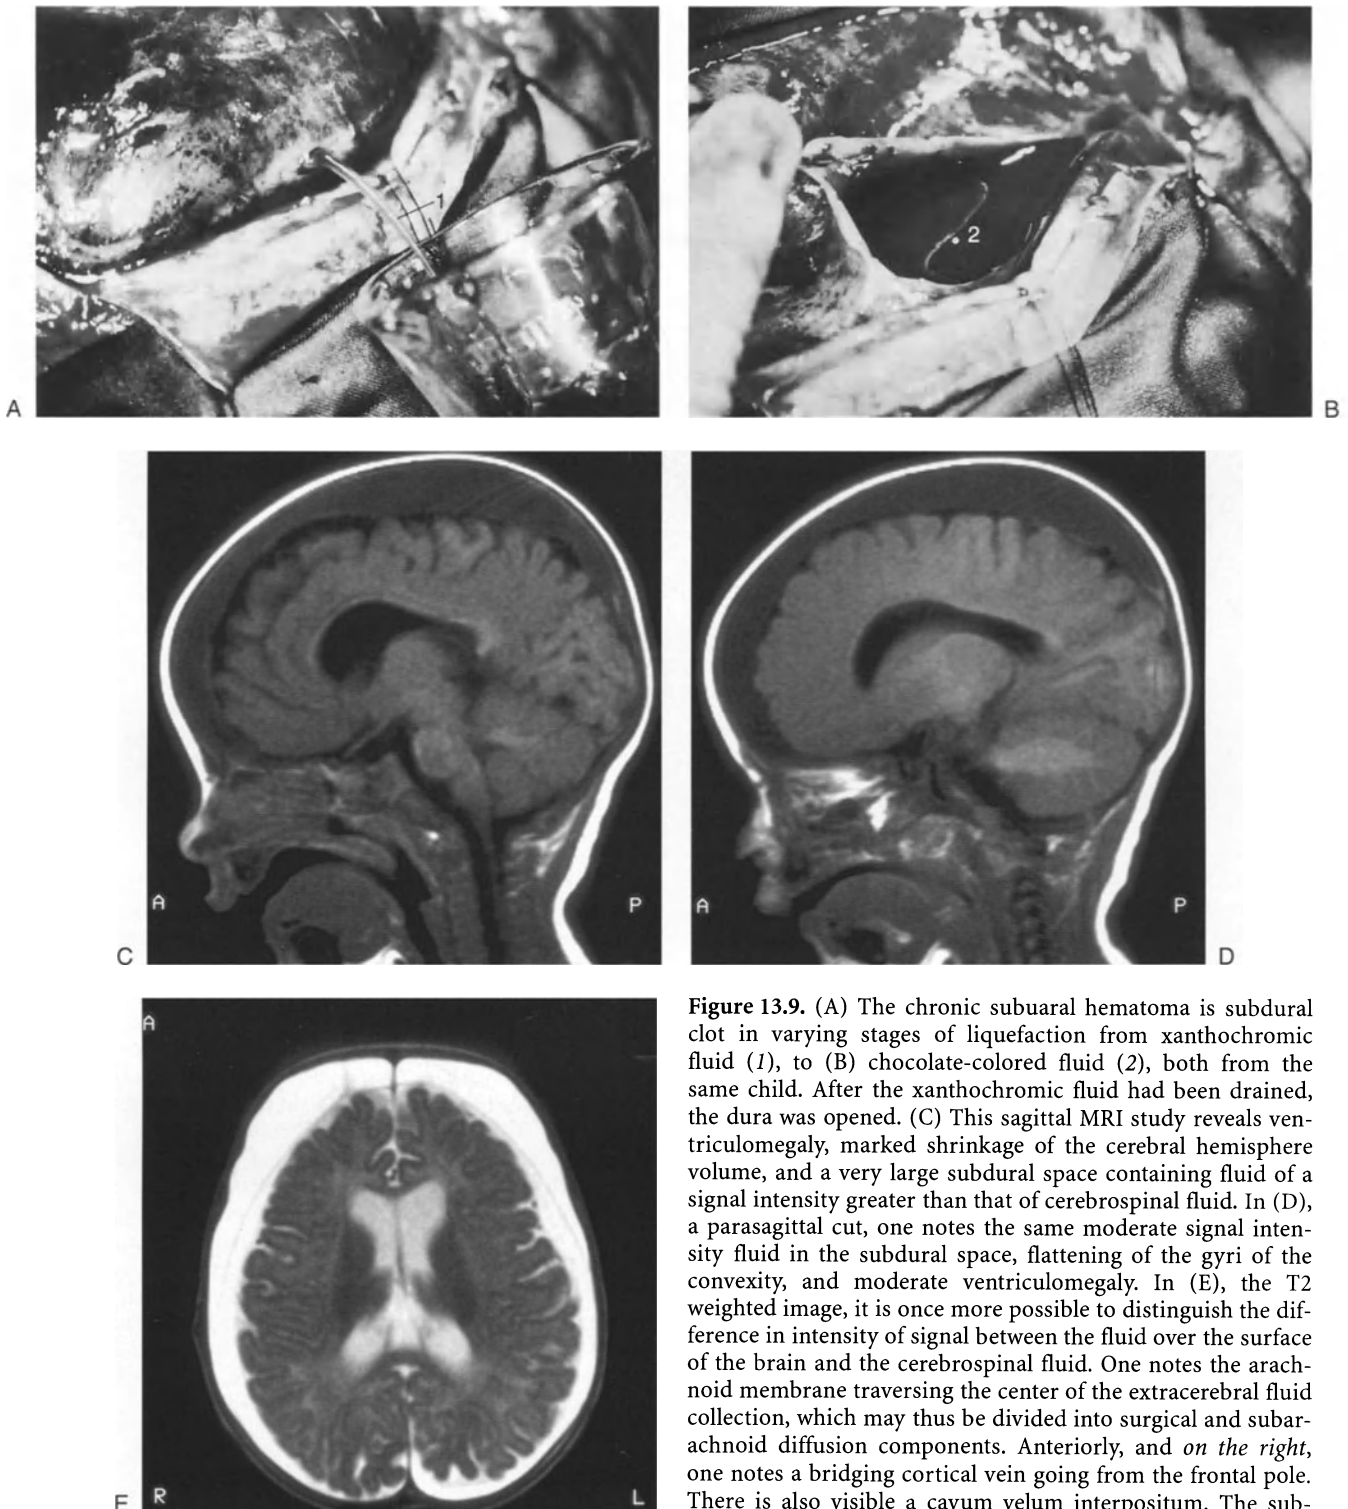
(A) The chronic subdural hematoma is subdural clot in varying stages of liquefaction from xanthochromic fluid (1), to (B) chocolate-colored fluid (2), both from the same child. After the xanthochromic fluid had been drained, the dura was opened. (C) This sagittal MRI study reveals ventriculomegaly, marked shrinkage of the cerebral hemisphere volume, and a very large subdural space containing fluid of a signal intensity greater than that of cerebrospinal fluid. In (D), a parasagittal cut, one notes the same moderate signal intensity fluid in the subdural space, flattening of the gyri of the convexity, and moderate ventriculomegaly. In (E), the T2 weighted image, it is once more possible to distinguish the difference in intensity of signal between the fluid over the surface of the brain and the cerebrospinal fluid. One notes the arachnoid membrane traversing the center of the extracerebral fluid collection, which may thus be divided into surgical and subarachnoid diffusion components. Anteriorly, and *on the right*, one notes a bridging cortical vein going from the frontal pole. There is also visible a cavum velum interpositum. The subarachnoid spaces and the sulci are well visualized.
